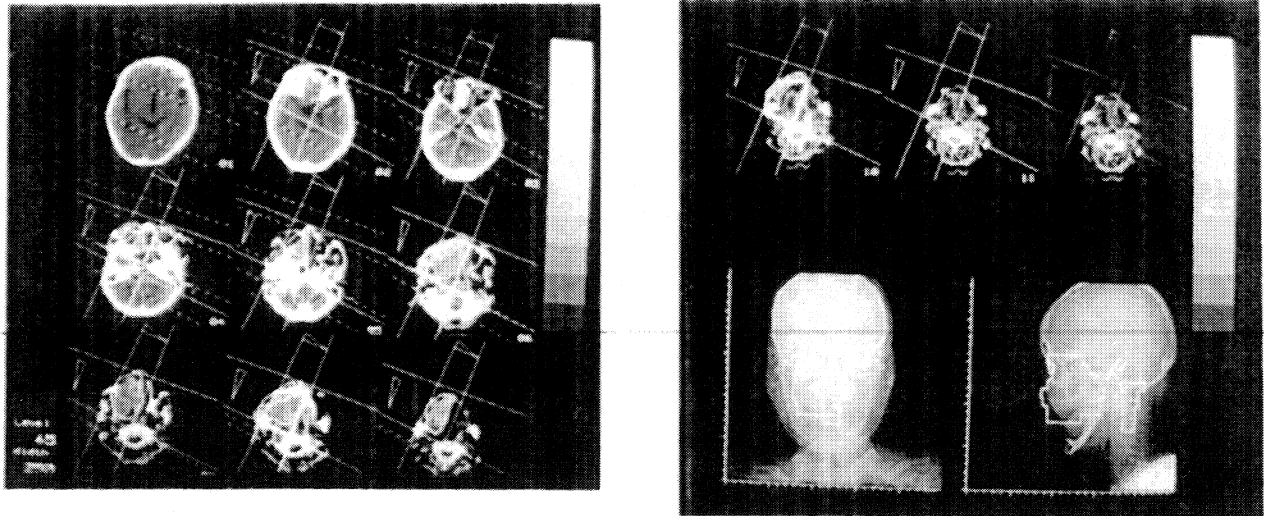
(a) Dose distributions and the field indication on multi CT images. The radiation field and iso-dose curves are indicated by solid lines, the block localization is indicated by broken lines, and the wedge filters are indicated by triangles (left). (b) Dose distribution and the field indication on multi CT images and two scannograms (right).
